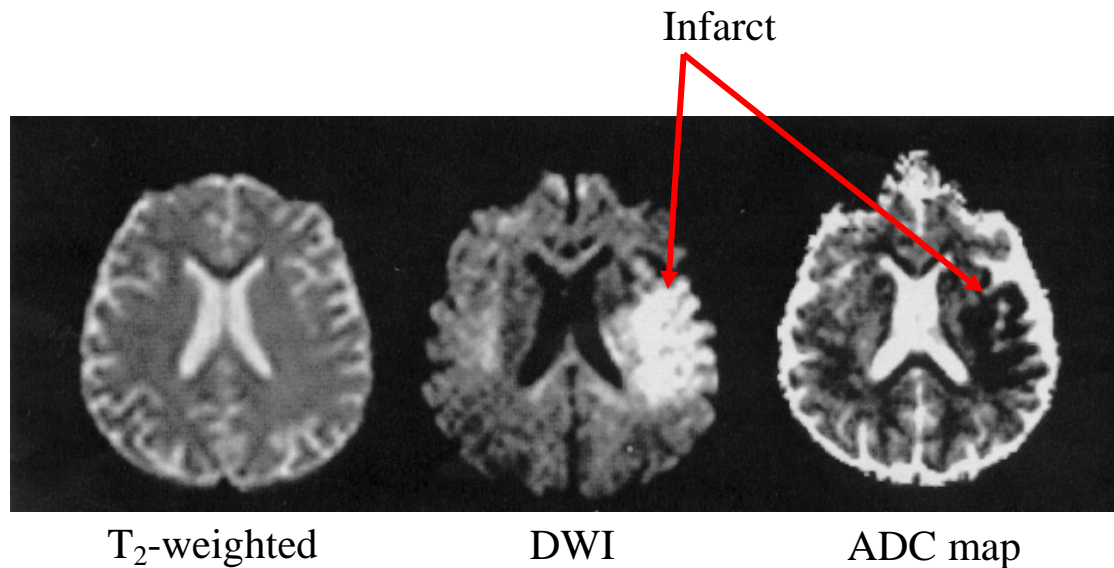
T₂-weighted image, diffusion-weighted image (DWI), and apparent diffusion coefficient (ADC) map of hyperacute ischaemic stroke in a human studied 2 hours after the onset of a right hemiparesis and global aphasia. Ischaemic damage appears bright on DWI and dark on ADC maps in left MCA territory, whereas the T₂-weighted image appears normal. (Baird and Warach, 1998)
